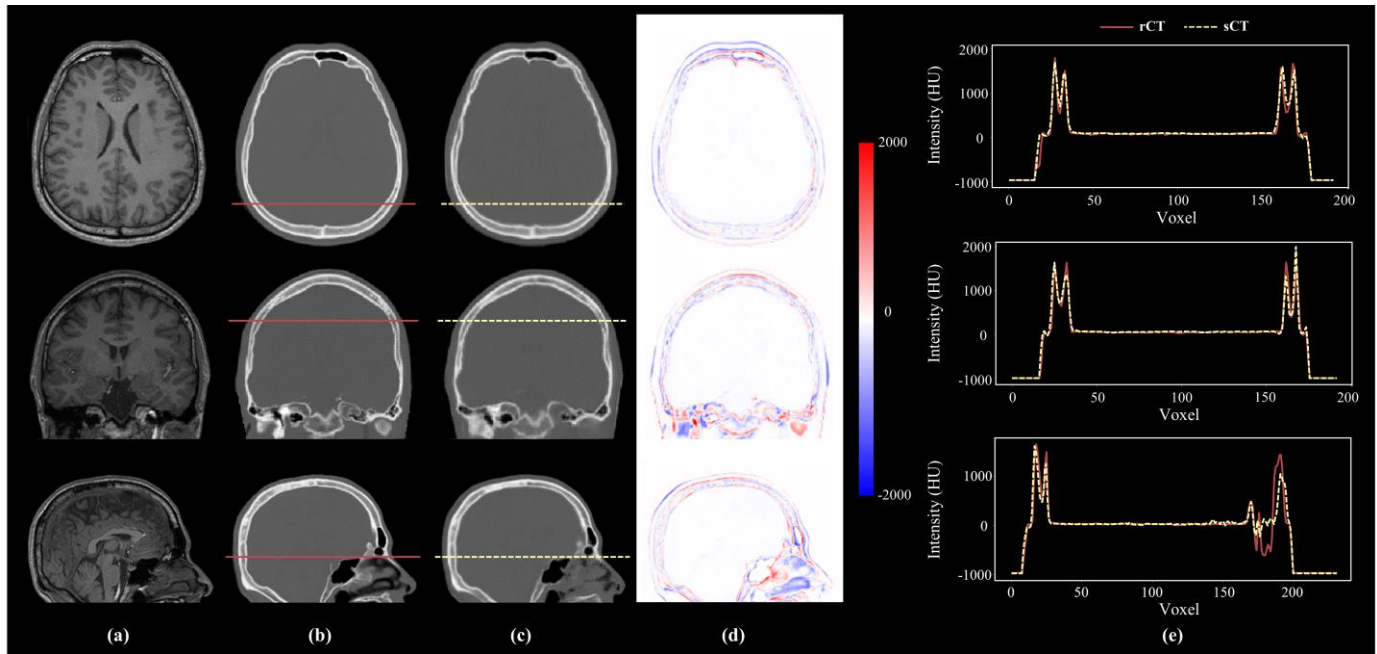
Axial, coronal, and sagittal view of (a) MRI, (b) rCT, and (c) sCT data from a representative test subject (S9). (d) Difference maps in HU intensity produced by subtracting rCT from sCT. (e) The profile plot along the red line in (b) and yellow dotted line in (c).
